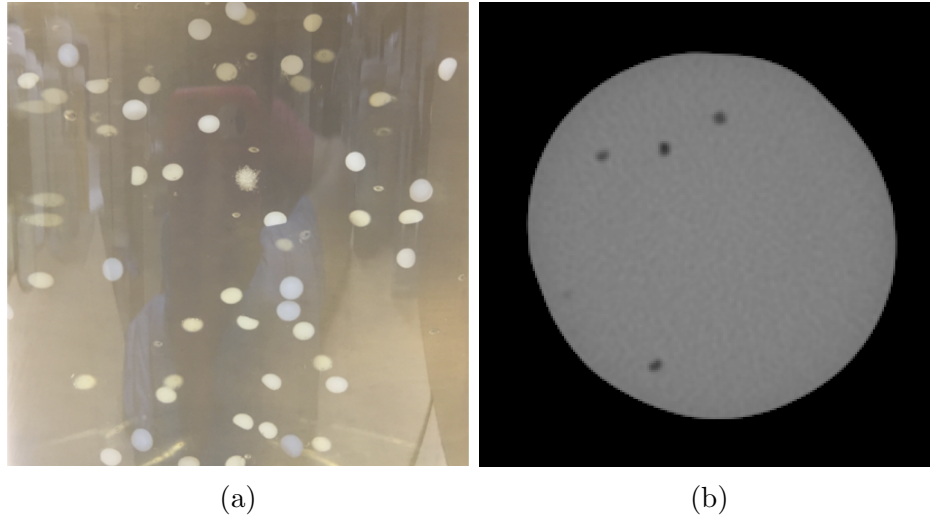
(a) Wax beads embedded within a non-deformable gel in a 1 L jar and (b) wax beads visible in the CT image of a deformable gel.
